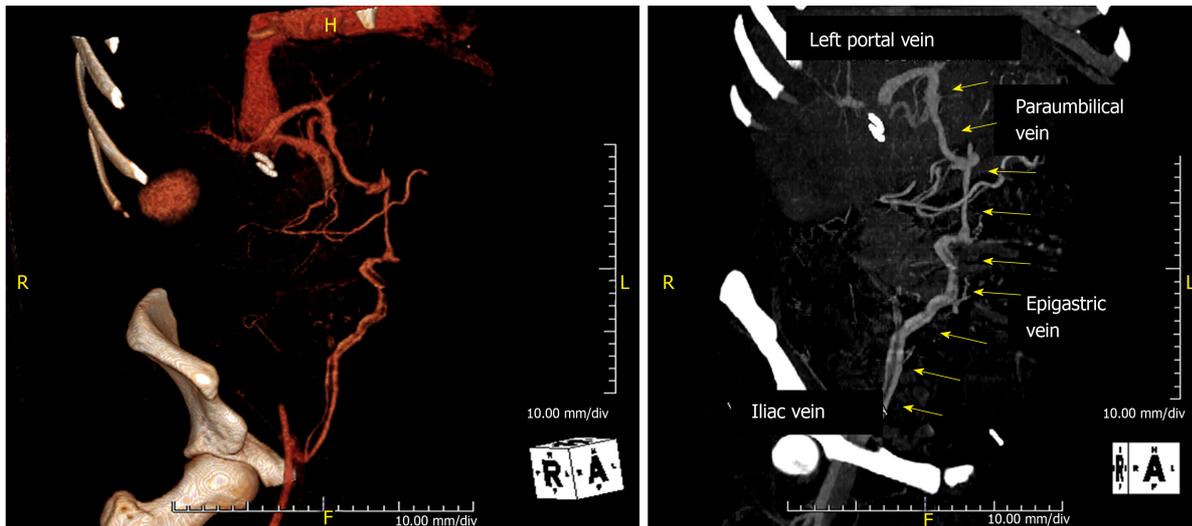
Paraumbilical shunt at computed tomography scan.
